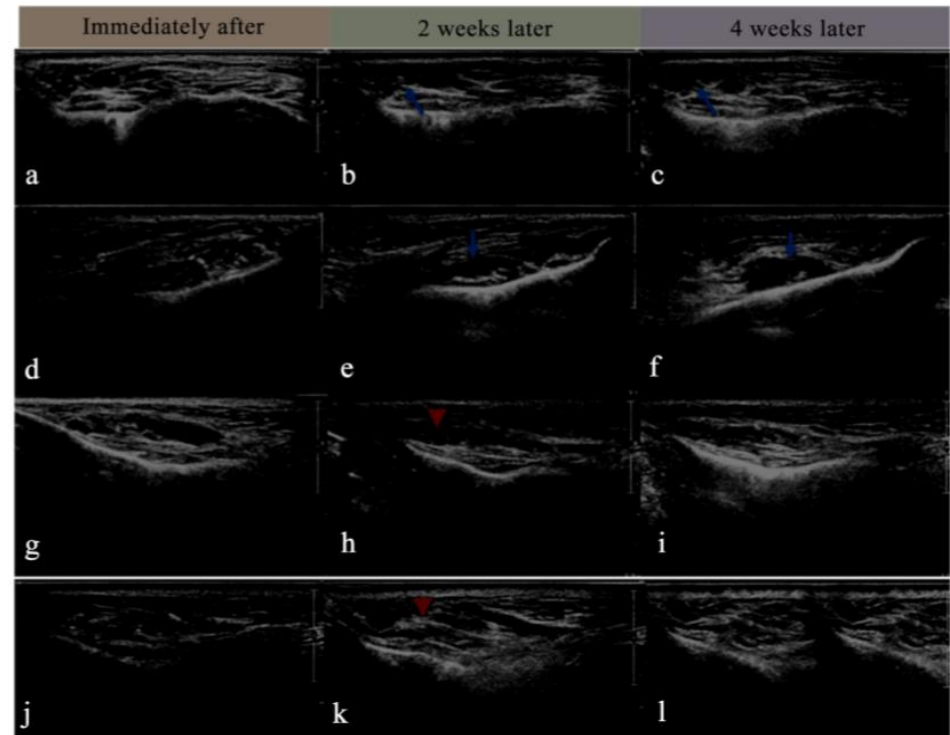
High-resolution ultrasound imaging immediately after HA injection (a, d, g, j), at 2-Week (d, e, h, k) and 4-week (c, f, i, l) follow up. Hydration of the HA would occur (arrows), and the ha would appear to be more heterogenous and hyperechoic (arrowheads) and may became completely unidentifiable with the surrounding tissues in the 4th week follow up (i, j).
